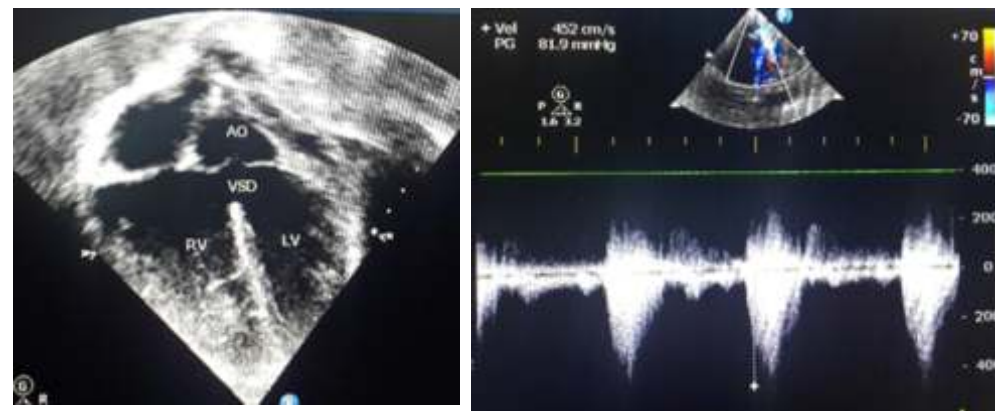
2D Echocardiography image of a 15 year old with TOF, a conotruncal lesion showing a malaligned VSD, overriding aorta and right ventricular
